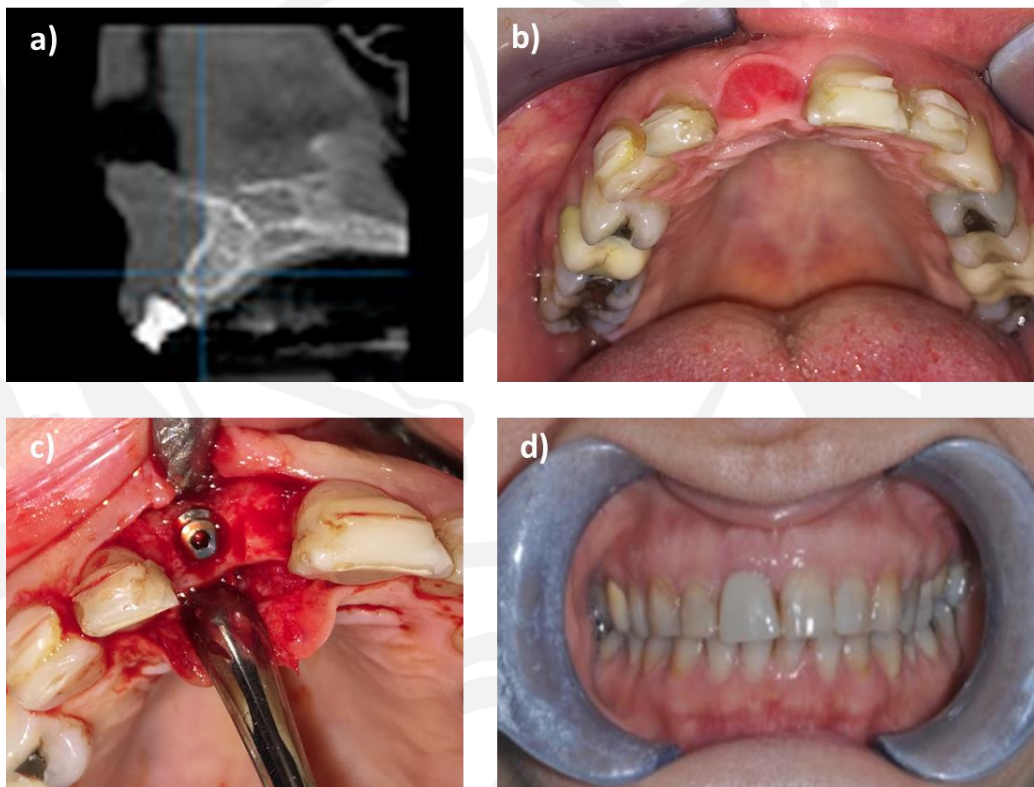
surgical site after three months: a) CT scan; b) clinical view; c) implant placement; d) last clinical examination.
